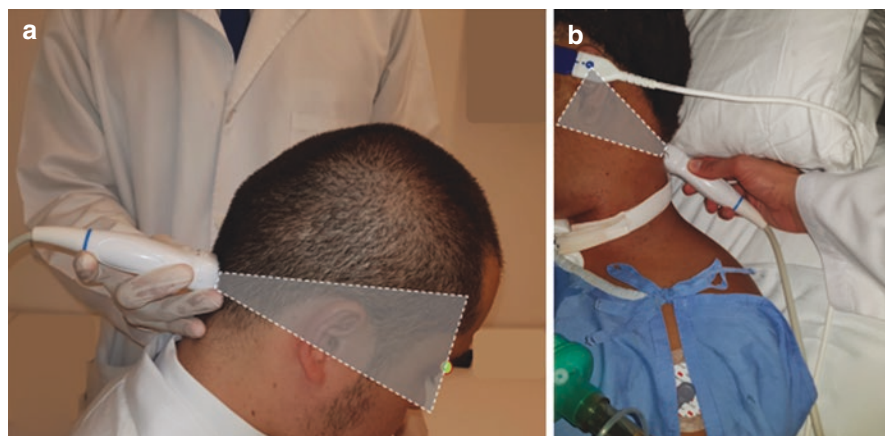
(a) Insonation of transforaminal window showing correct angle of insonation with ultrasound beam toward the nasion (green dot). (b) Transforaminal window insonation in a critical care patient. Note how a folded pillow helps to place the transducer in proper position. (Author: Jorge Carrizosa)
